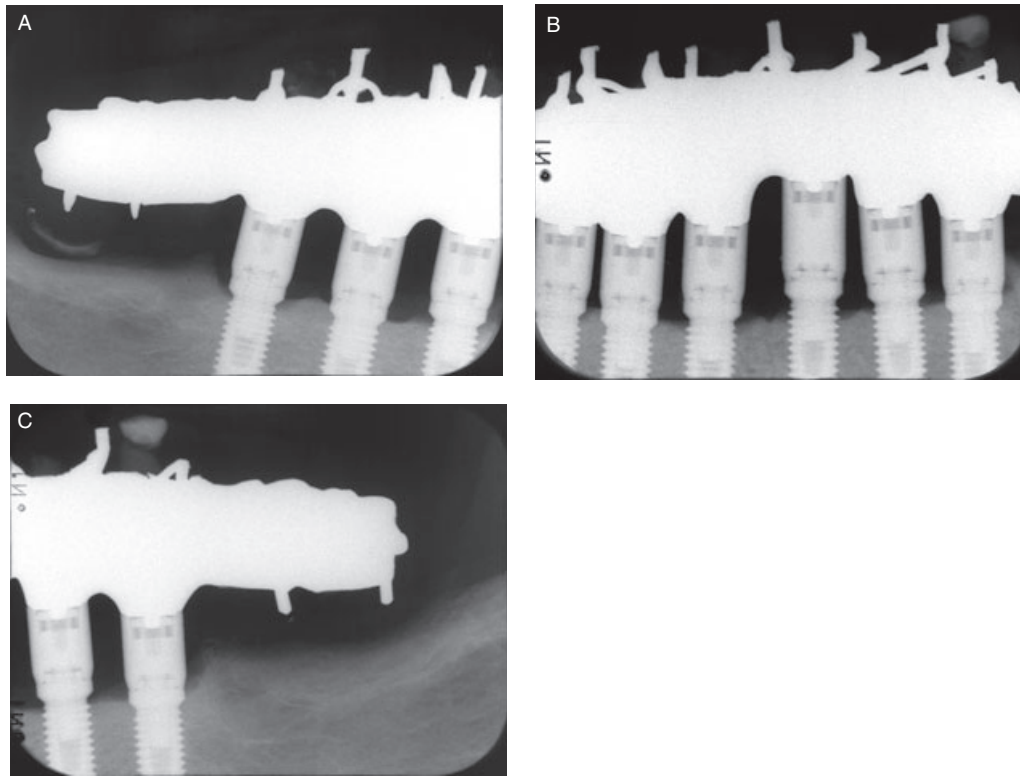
Ninety-year-old woman who at the age of 66 was treated with six mandibular implants. Radiographs 24 years after treatment demonstrate good marginal bone level.
